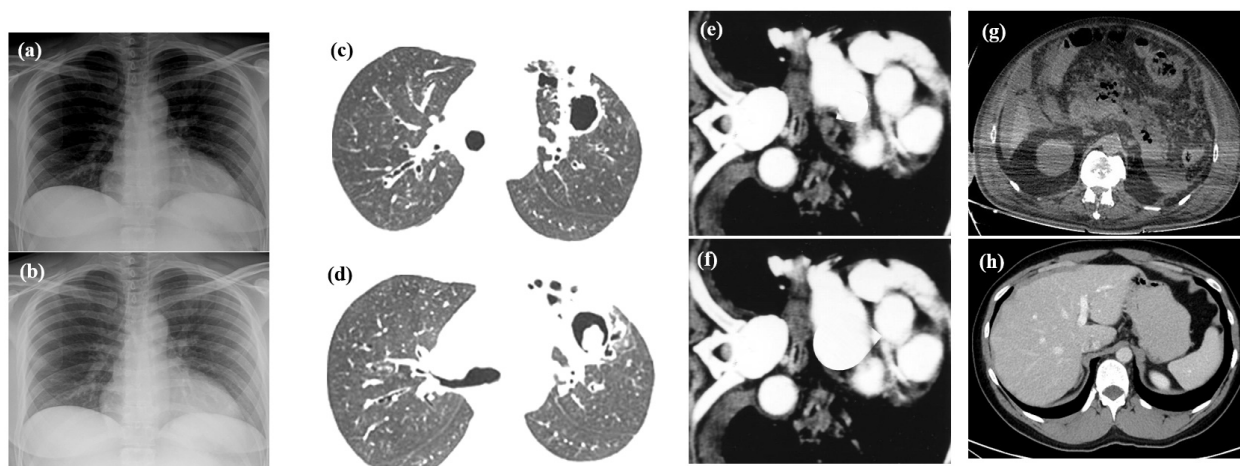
Chest X-ray and CT scan analyses of patient (a) before treatment (CXR) (b) after treatment (CXR) (c) CT scan of lungs before treatment (d) CT scan of lungs after treatment (e) CT scan of mediastinum before treatment (f) CT scan of mediastinum after treatment (g) CT scan of abdomen before treatment (h) CT scan of abdomen after treatment.
